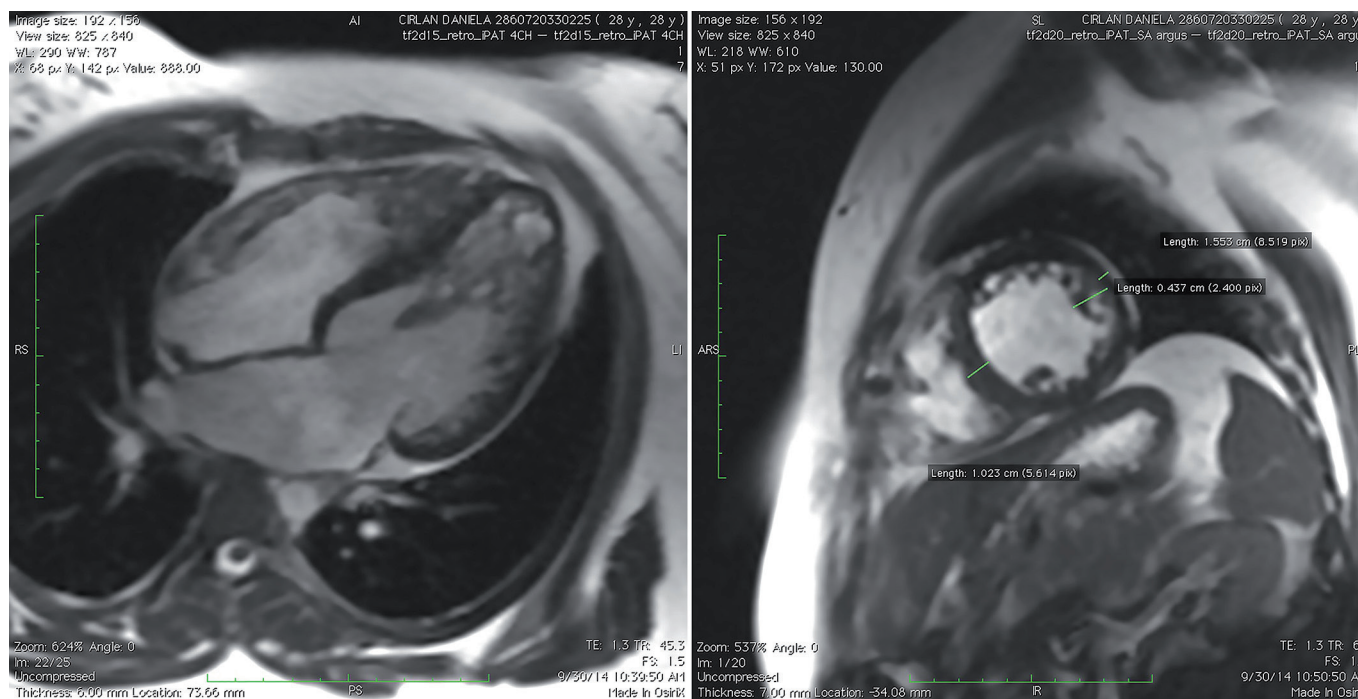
Cardiac MRI exam showing left ventricular noncompaction in four chamber (left) and short-axis (right) views.
